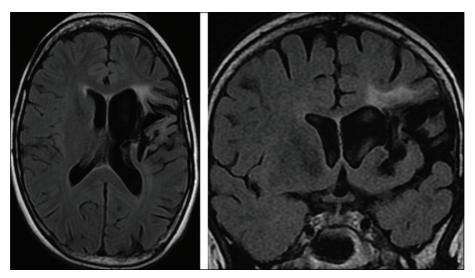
Axial and coronal FLAIR MRI.
